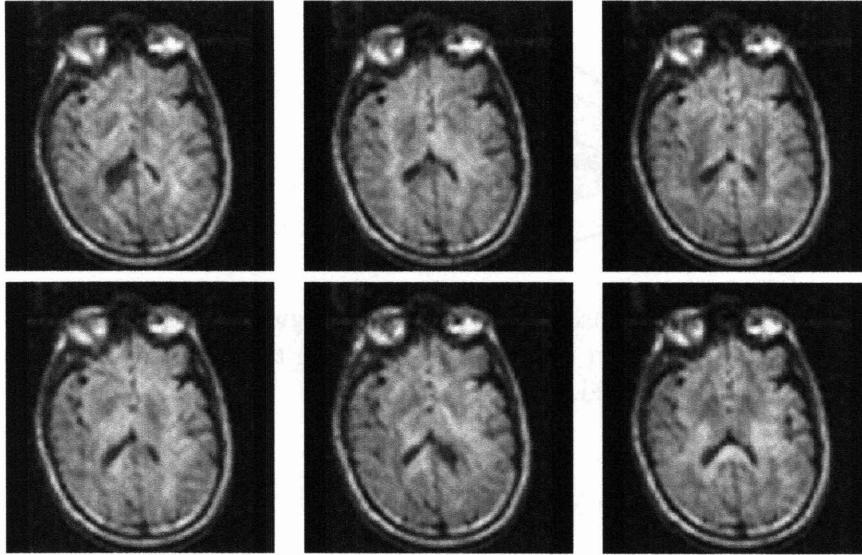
Six diffusion-weighted images (the minimum for tensor calculation). In diffusion MRI, magnetic field gradients are employed to sensitize the image to diffusion in a particular direction. The direction is different for each image, resulting in a different pattern of signal loss (dark areas) due to anisotropic diffusion.
